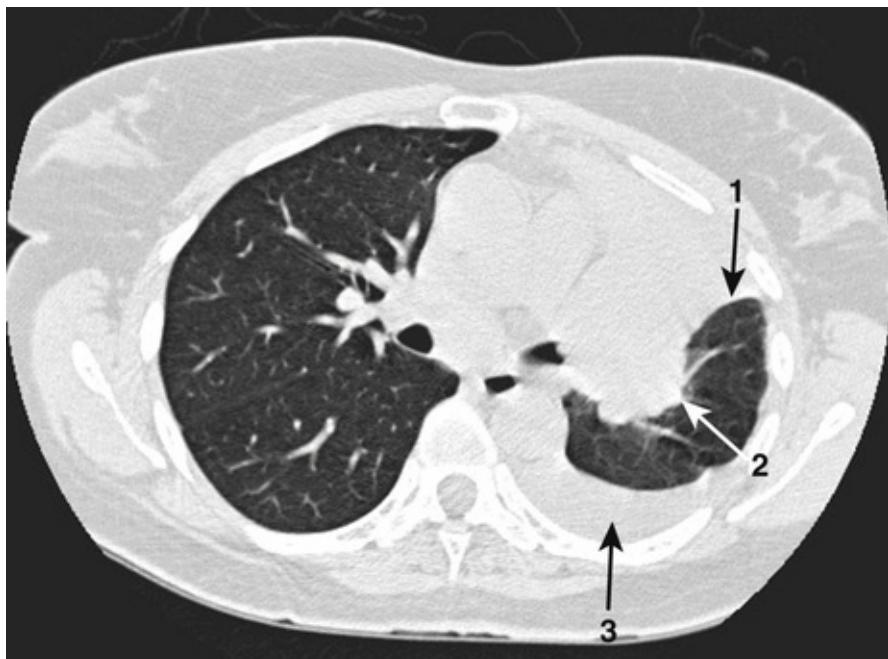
Left upper lobe collapse. Image shows the appearance of left upper lobe collapse on the lung windows of a CT scan. There is a dense white area in the left lung anteriorly with no air bronchograms and a curved edge anterolaterally (1). The area nearer the hilum, which is convex and has irregular margins (2), is a tumour causing bronchial occlusion and distal collapse. There is an associated small left pleural effusion (3). This image nicely demonstrates the difference between the smooth edge of lung collapse and the irregular border of a lung malignancy.
